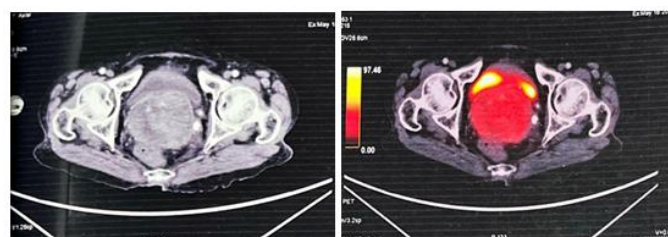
PET CT showing lesion of size 6.8 x 6.3 x 6.6 cm involving cervix.
